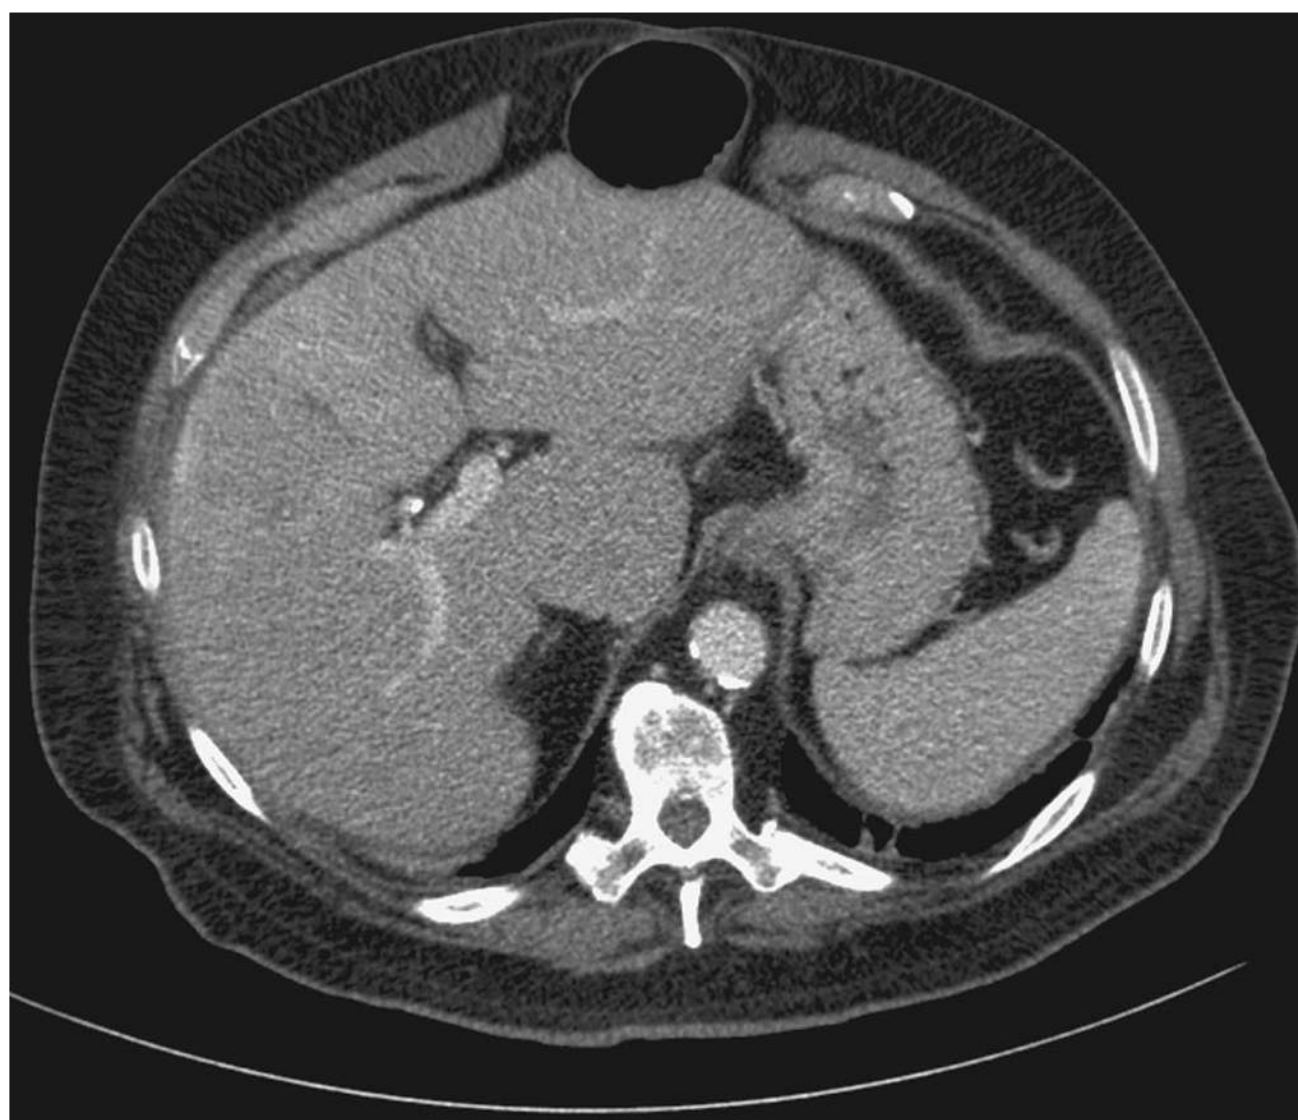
■ Incisional Hernia CT Scan.
